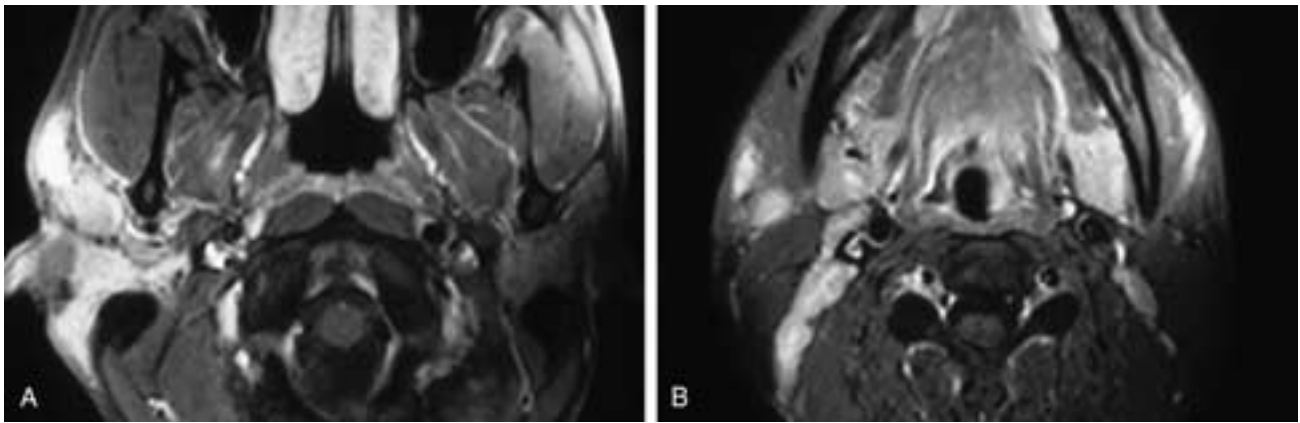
Axial T1-weighted, fat-suppressed, contrast-enhanced MR images through the parotid glands (A) and more caudally in the neck (B) show an enhancing mass in the right parotid gland and adjacent soft tissues. There are also involved right level II and V nodes. This patient had Kimura's disease.
